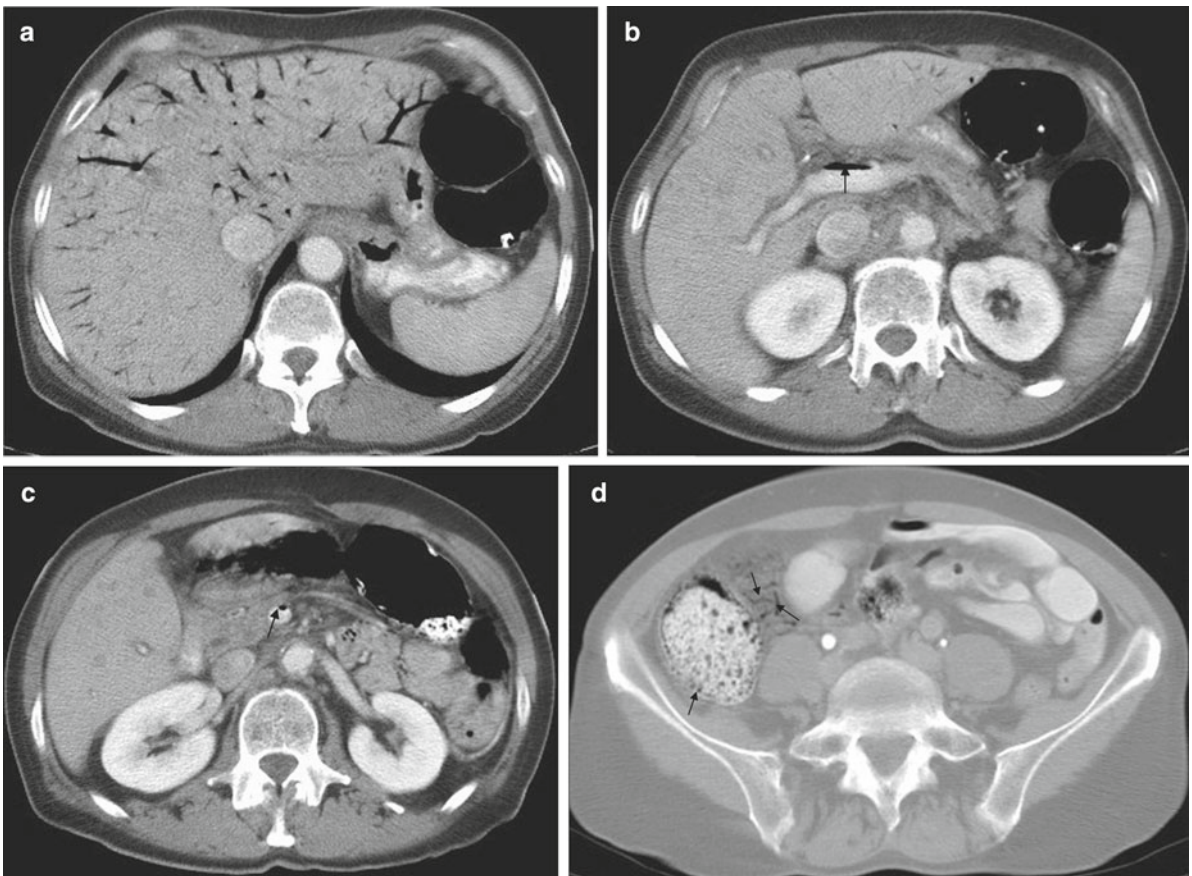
A 72-year-old man with severe abdominal pain and bloody diarrhea. (a) Axial oral and intravenous contrast enhanced CT image through the level of the upper abdomen shows air in the portal venous system. (b) Axial oral and intravenous contrast enhanced CT image through the level of the portal vein shows air-contrast level in the portal vein (*black arrow*). (c) Axial oral and intravenous contrast enhanced
